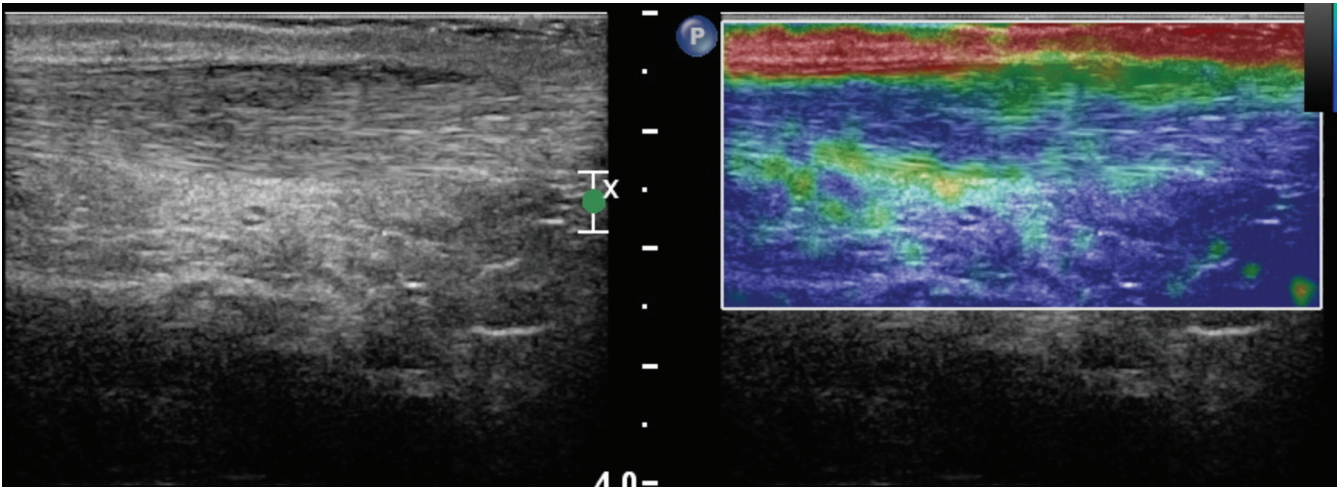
Ultrasound elastography of the same area of the Achilles tendon after treatment shows that soft (red) area of tendinitis on the initial study has resolved, and now there is a small area of green (intermediate stiffness), which may represent either scar formation or continued healing.
